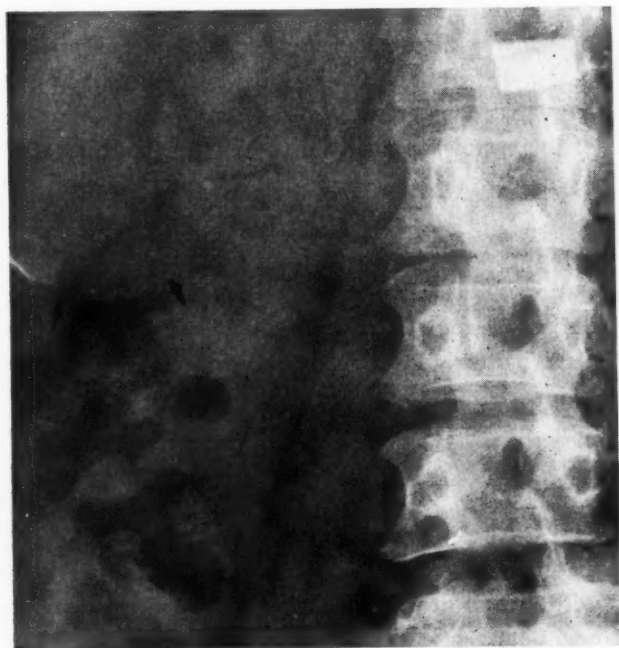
X-ray shows calcium shadow due to encapsulated sponge in the region of the gall bladder. Case 2.
